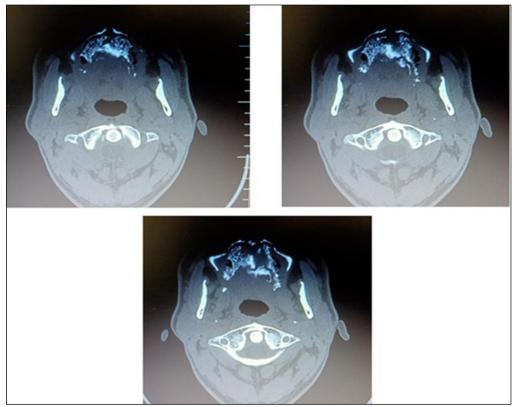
CT Axial View Reveals Osteolytic Changes.
